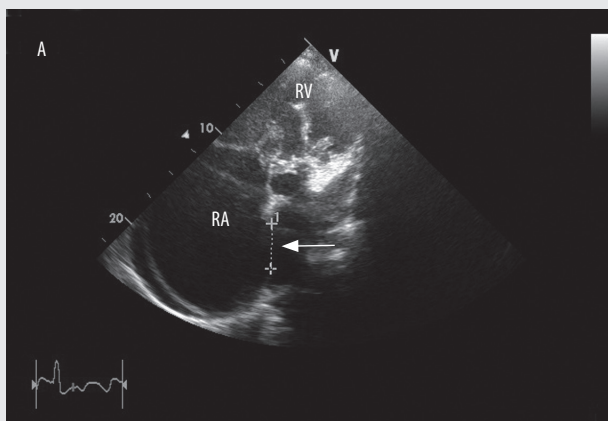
Echocardiography. Four chamber view. Large atrial septal defect (ASD II) with left-to-right shunt (arrow). RA – right atrium, RV – right ventricle. A. 2D imaging. B. Colour Doppler imaging
